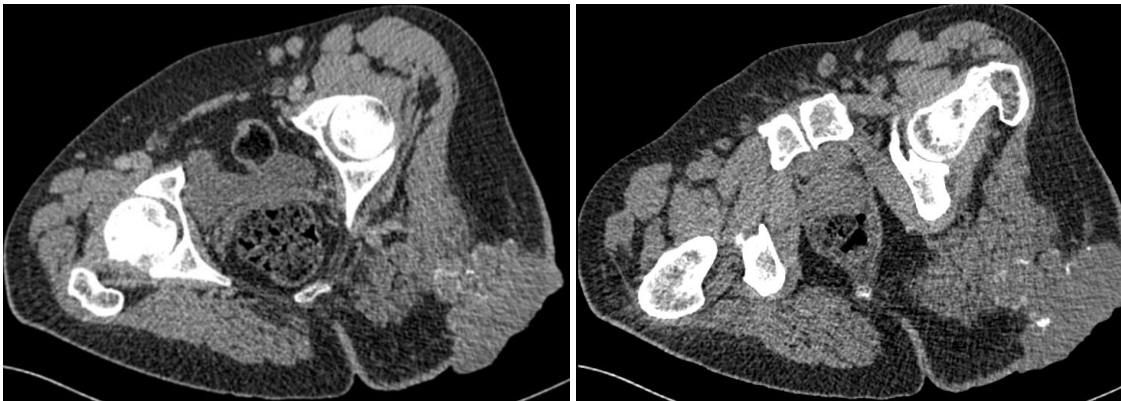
CT axial slices without and with contrast injection
